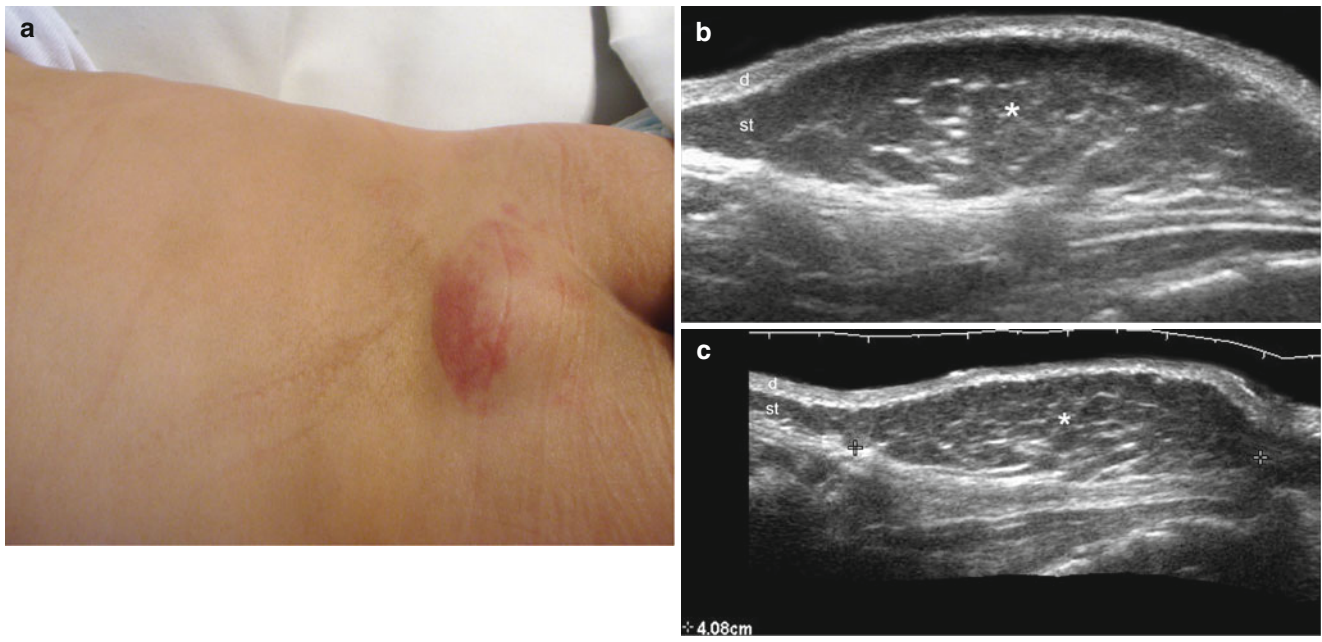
(a–c) Hypertrophic lipodystrophy (congenital). (a) Clinical lesion in the lumbosacral region shows swelling and erythema. (b) Gray scale ultrasound image (transverse view) demonstrates a focal region with increased thickness of the subcutaneous tissue. No well-defined nodular structure or capsule can be detected. (c) Gray scale
